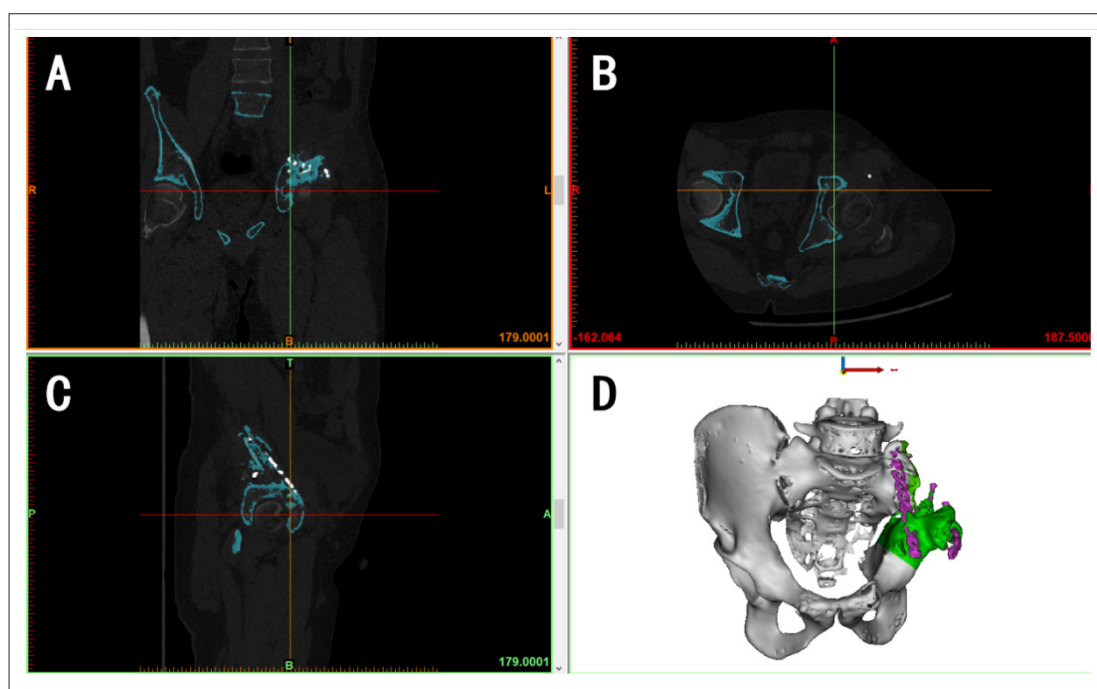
Three-dimensional pelvic model reconstruction utilizing patient computed tomography (CT) data. (A) CT coronal view. (B) CT axial view. (C) CT sagittal view. (D) 3D-reconstructed pelvic model.
